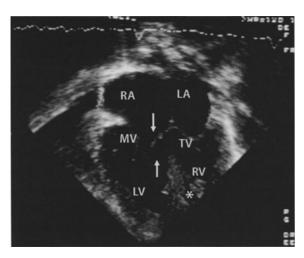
Double discordance: echocardiography with 4-chamber view showing the atrioventricular discordance and a large ventricular septal defect (white arrows), with the moderator band (white asterisk) identifying the right ventricle (*LA* left atrium, *LV* left ventricle, *MV* mitral valve, *RA* right atrium, *RV* right ventricle, *TV* tricuspid valve) (photograph courtesy of Dr. Michael Rigby)
